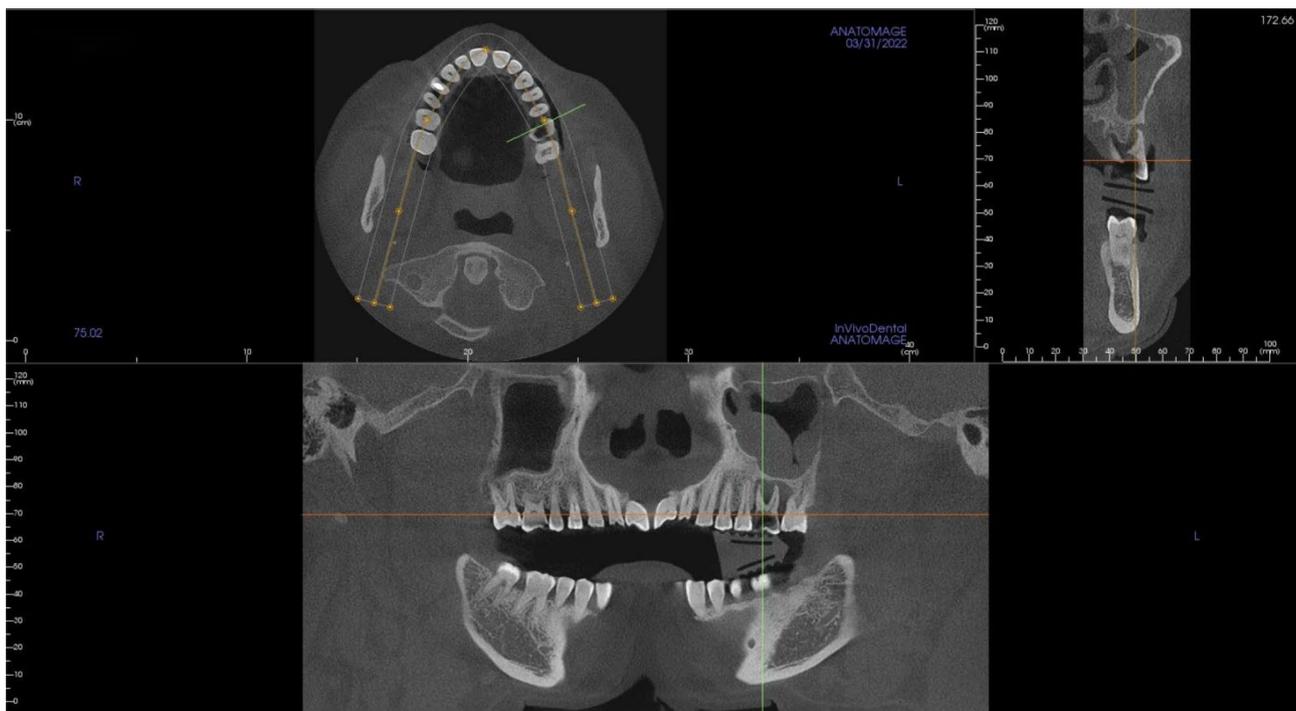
Cone-beam CT (CBCT) was performed before implantation
